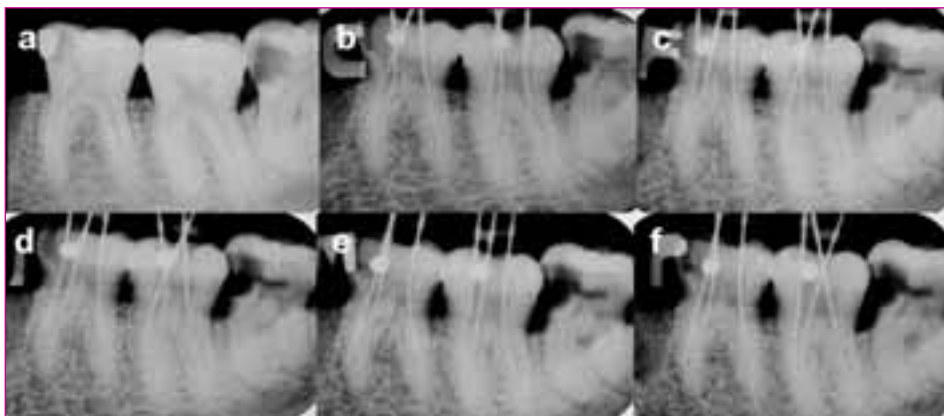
Sequence of periapical radiographs taken with Insight films.
